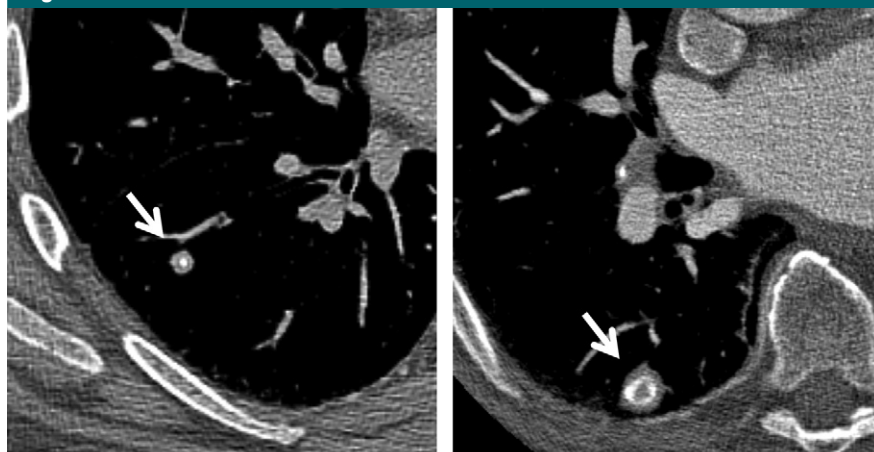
(a) CT image shows a smoothly margined solid nodule with central calcification, typical of a healed granuloma. No further CT follow-up is recommended for such nodules. (b) CT image shows a smoothly margined solid nodule with laminar calcification, typical of a healed granuloma. No further CT follow-up is recommended for such findings.
